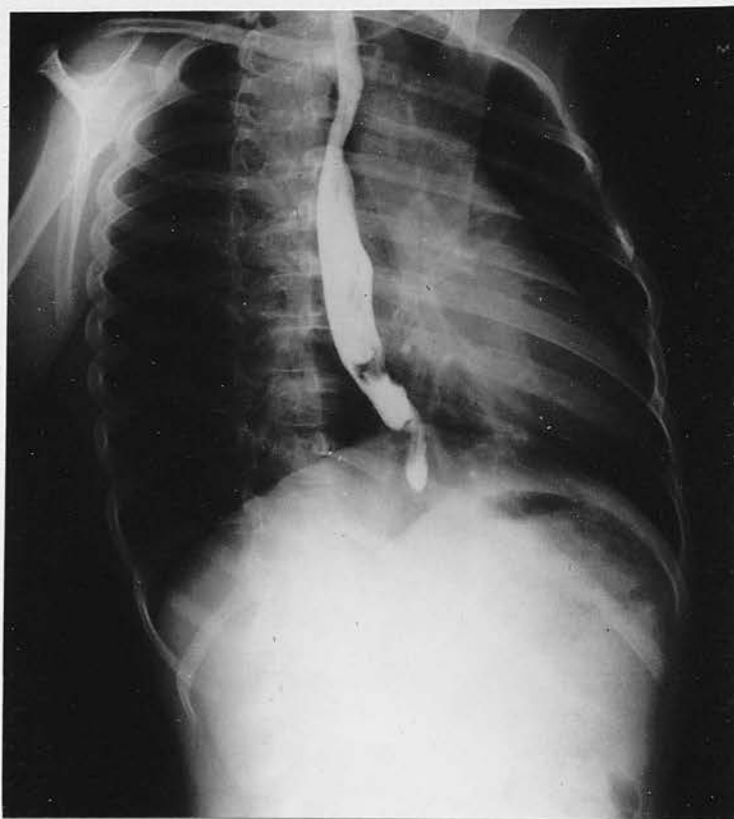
Radiograph of Case 51. Persistence of Left Atrial enlargement 1yr. after ligation of Patent Ductus Arteriosus.
